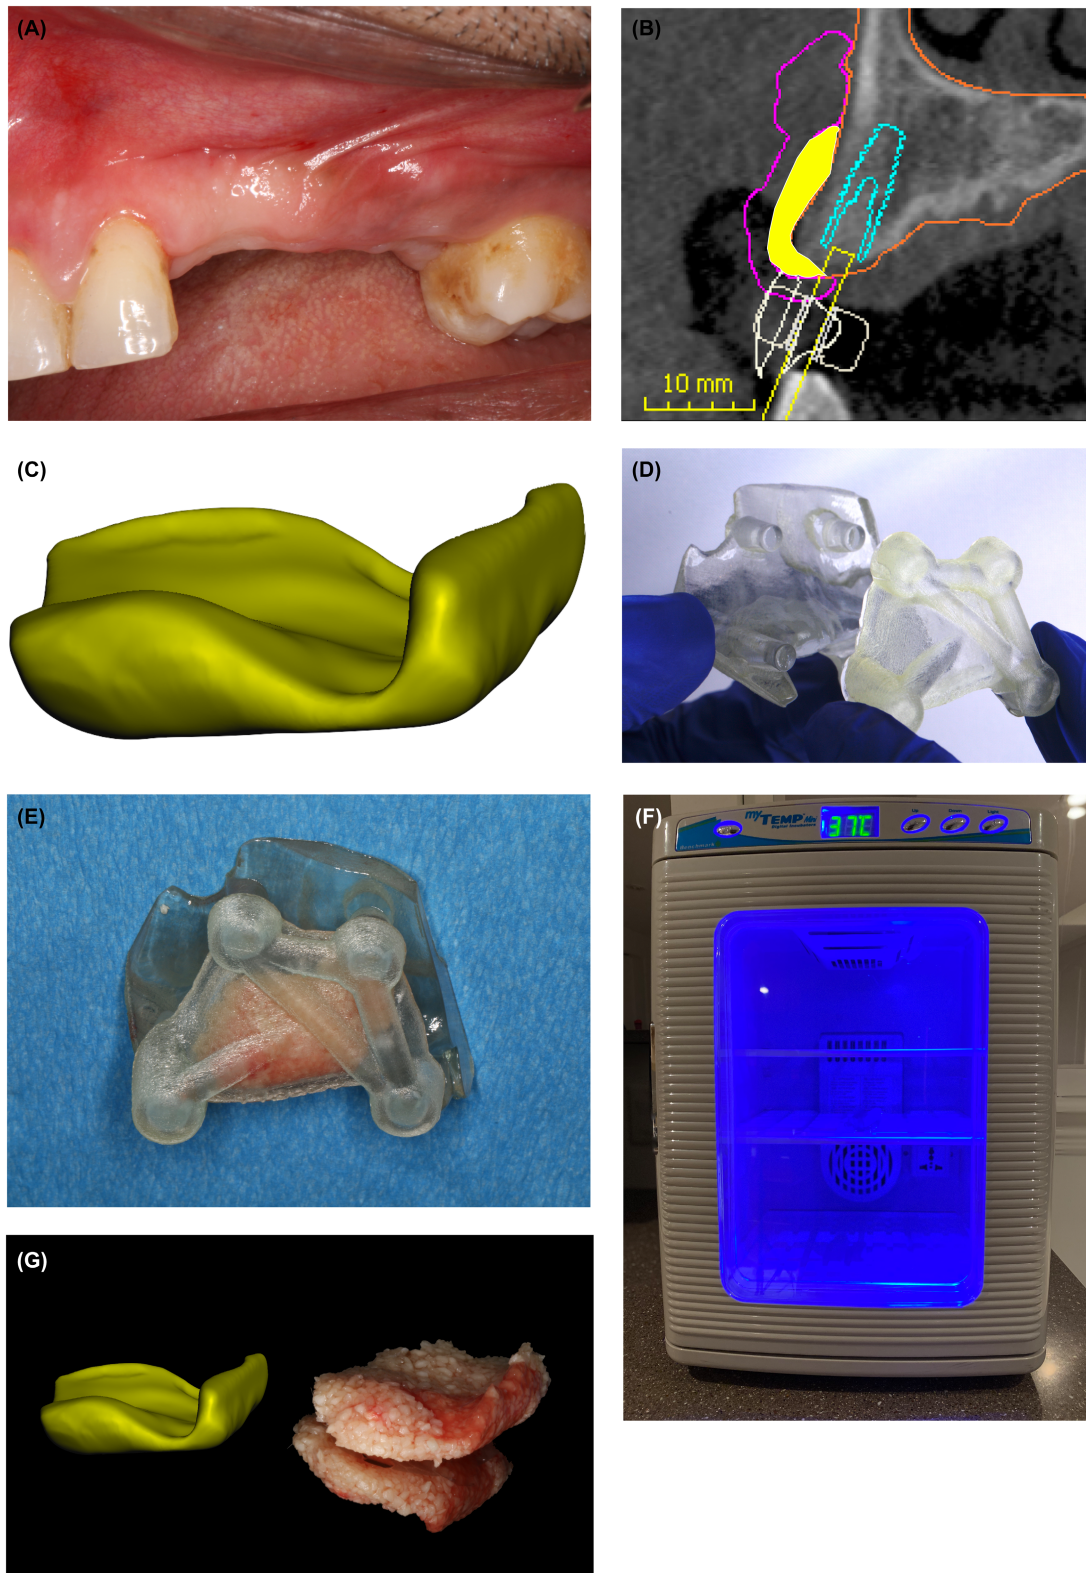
(A) Preoperative image of the edentulous ridge. (B) CBCT DICOM cross-sectional view showing the digital planning of the guides, molds, implant, and bone graft shown in yellow. (C) Custom 3D-rendered digital bone graft. (D) Bone mold orientation for seating is shown with the 3D printed models. (E) Sticky bone inserted into the bone mold. (F) Bone mold with incorporated sticky bone placed into an incubator at 37°C. (G) After 15 min, note the custom-made 3D bone graft. (H) Occlusal view of the custom bone graft in place as planned digitally. Case performed by Naheed Mohamed.
